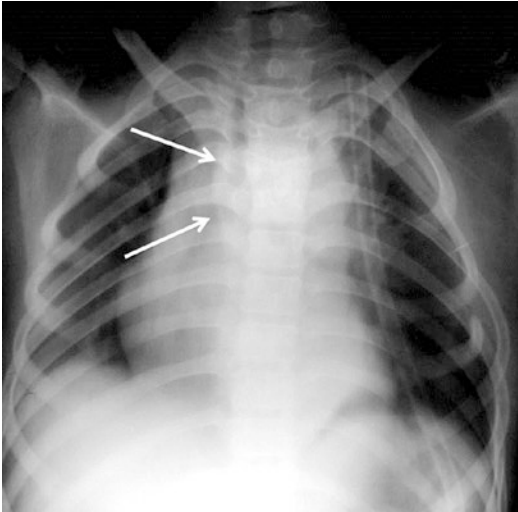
Thoracic paraspinous abscesses appear as oval soft tissue densities adjacent to the spine on a chest radiograph (*arrows*), sometimes with calcifications within the wall of the abscess
